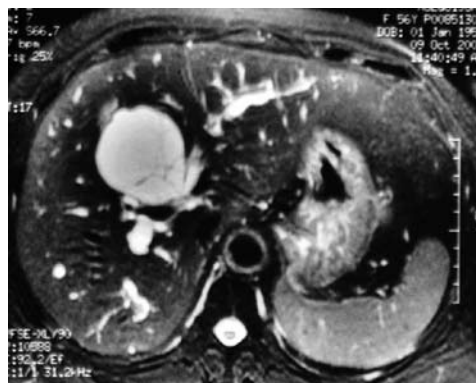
Magnetic resonance imaging (MRI) showing different bile signals between the right and left intrahepatic ducts in a multiloculated lesion with internal septation.
